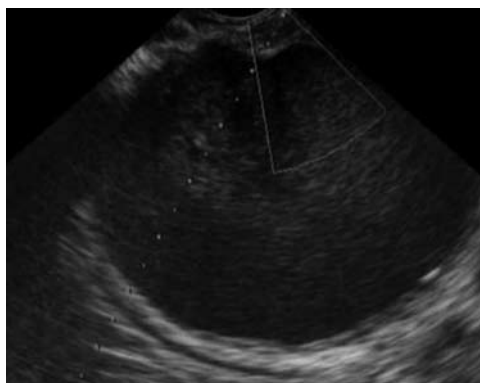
Ultrasonographic image of the pancreatic fluid collection to identify an appropriate puncture route which has no interposing vessels.
